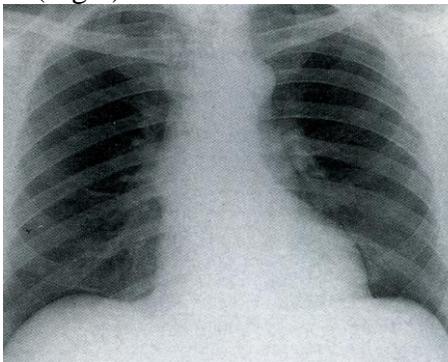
Hypertension. The chest X-ray is usually normal in mild to moderate hypertension, but cardiac enlargement associated with left ventricular hypertrophy (as here) may occur in the later stages. There is no evidence of cardiac failure in this patient.
